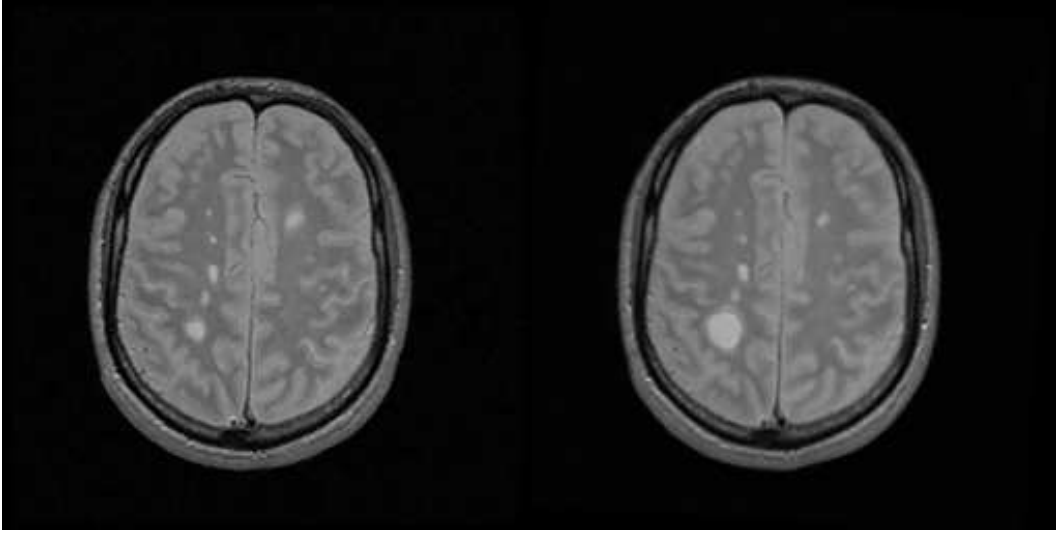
Two registered slices of a real patient with MS disease, and with a two months interval, imaged with first echo  $T_2$  weighted MRI.
